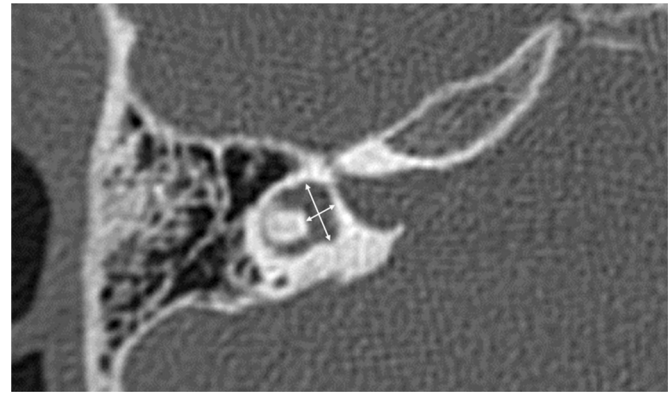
Measurements of the vestibule in axial HRCT scans.
